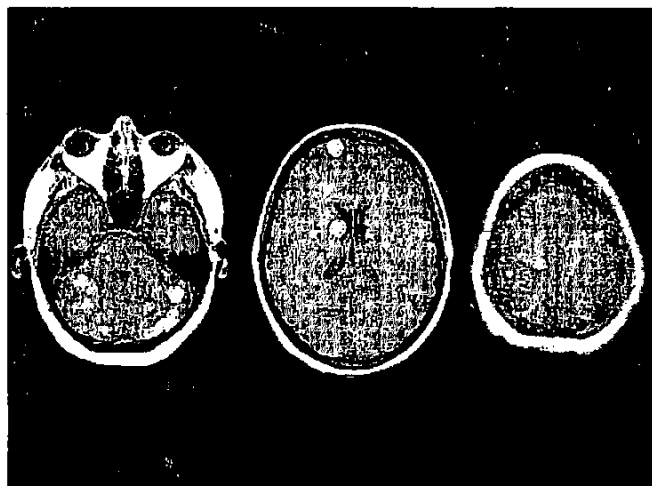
Contrast-enhanced brain Magnetic Resonance Imaging (MRI) from a woman with breast cancer. Despite the presence of innumerable metastases, she presented without significant focal symptoms, as if the bilateral lesions “balanced” each other.
